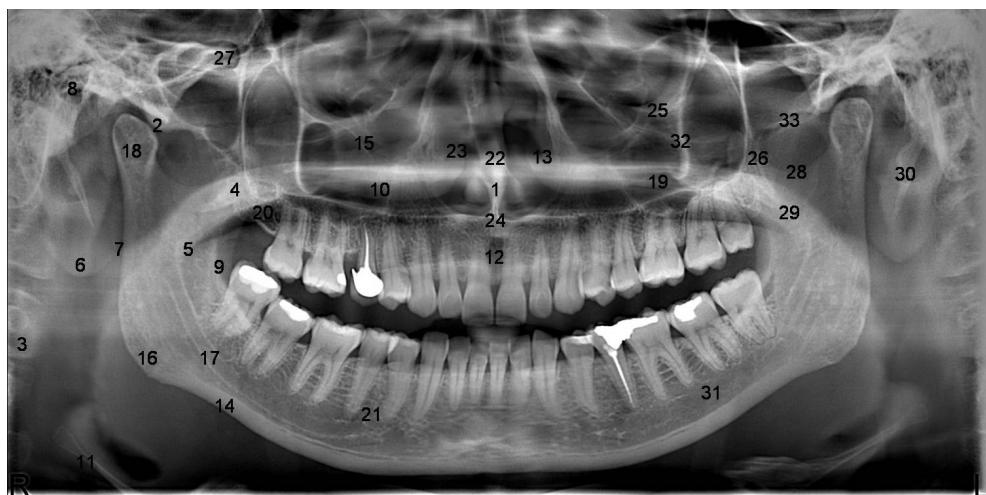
Panoramic radiograph with marked anatomic structures
